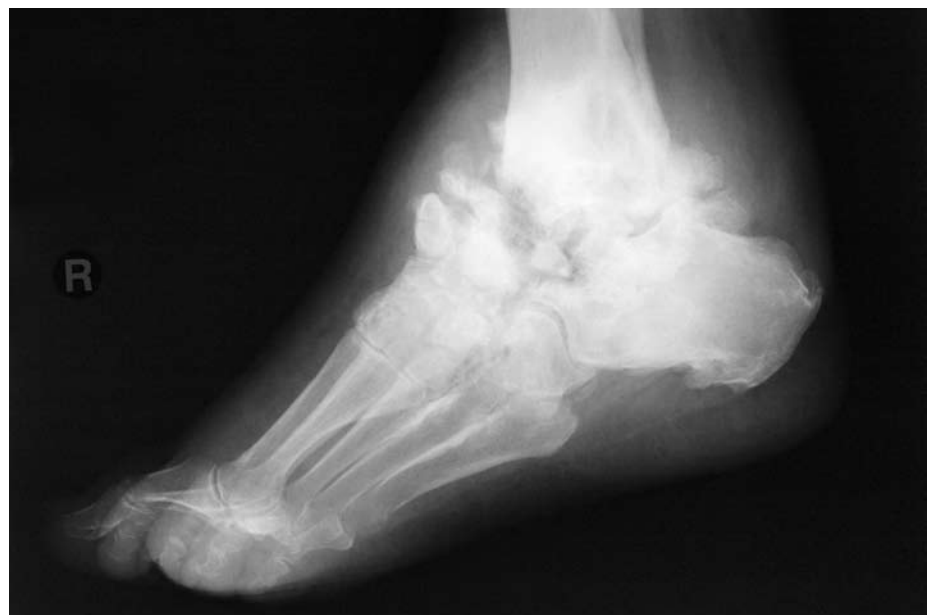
Plain radiograph revealing chronic destructive effects of Charcot's osteoarthropathy in later stages. There may be no radiographic changes evident in the acute stages of the condition.
